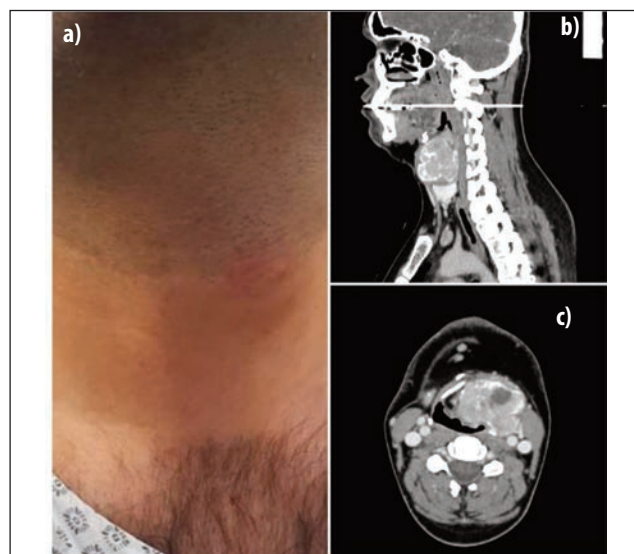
a) Anterior Neck swelling with reddish discoloration of overlying skin. b) Sagittal view on CT scan. c) Transverse view on CT scan.
